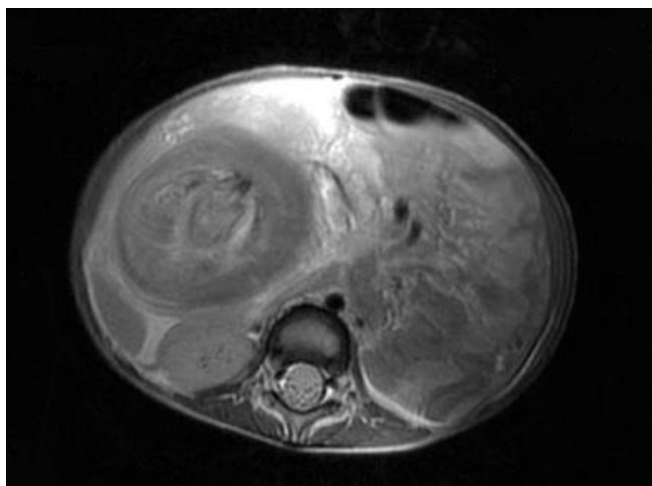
Burkitt lymphoma, abdominal MRI.
